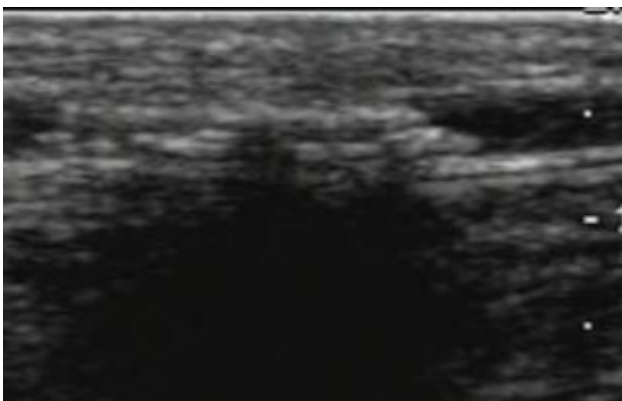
An ultrasound image of a thickened
